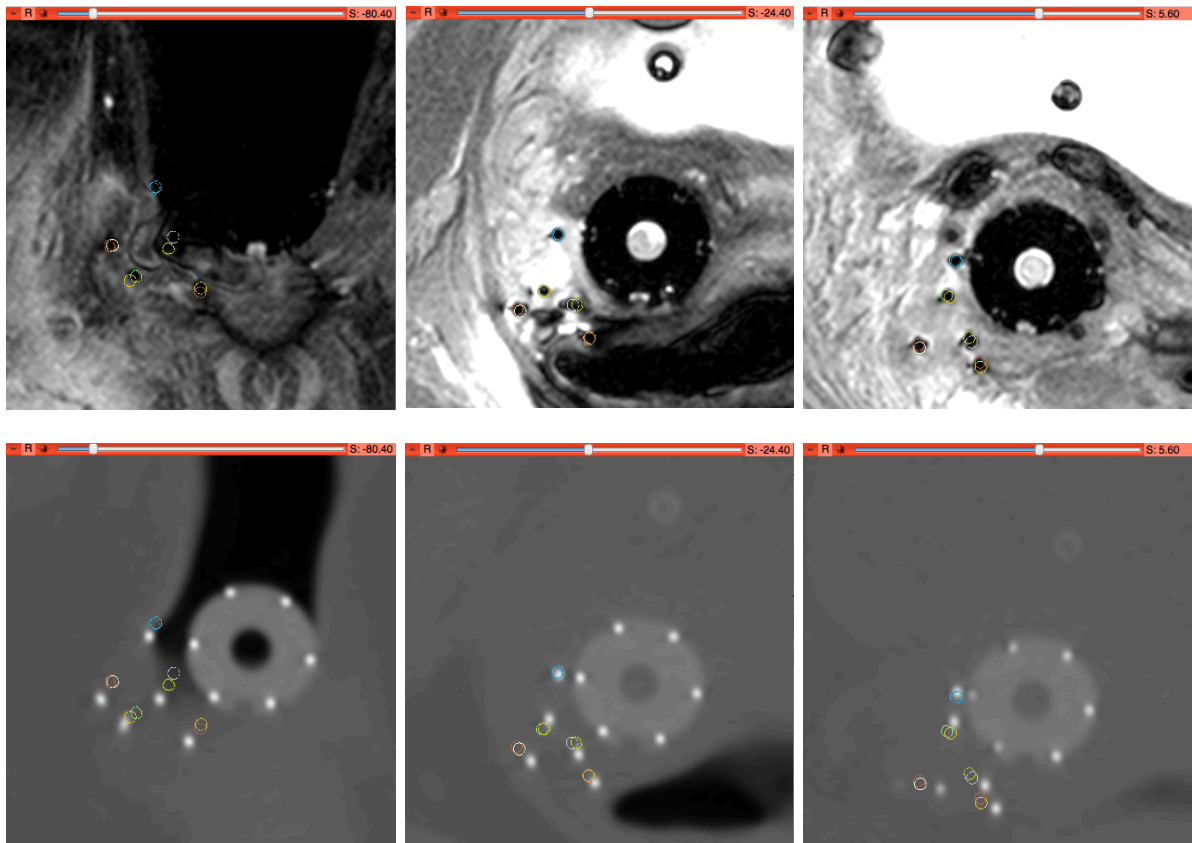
Comparison in axial views of the position of the needles between MR (first row) and CT images (second row) for the same case, in different slices.
